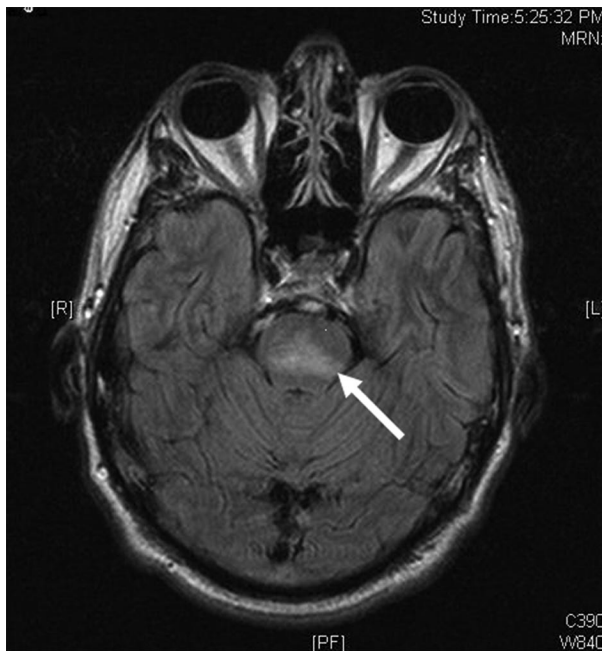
MRI of Brain. T2-weighted MRI of the brain demonstrating pontine demyelination (arrows). This patient had a history of alcoholism and cirrhosis and presented with initial serum sodium of 108 mEq/L. Treatment resulted in a rise of the serum sodium to 130 mEq/L in the first 12 hours. Subsequently, the patient developed quadriplegia and mental status changes 2 days later. There is predominant high intensity signal (T2-weighted) in the pons consistent with a demyelinating process. MRI, magnetic resonance imaging.
